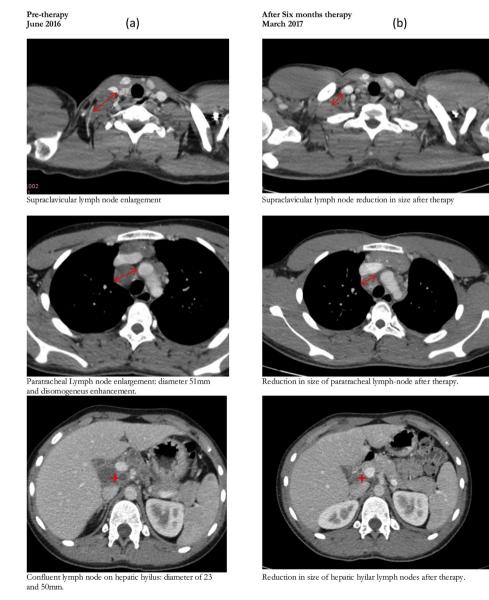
Pre- and post-therapy CT scan.
